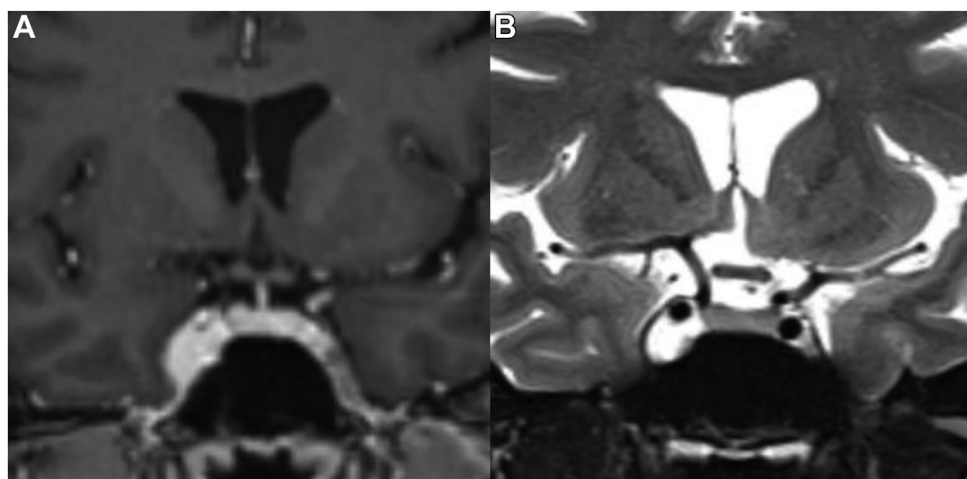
Coronal magnetic resonance images demonstrate a mass within the right cavernous sinus mass. The lesion exhibits homogeneous enhancement on postgadolinium T1-weighted image (A). Bright T2 signal intensity is noted (B), a feature unlikely in a
